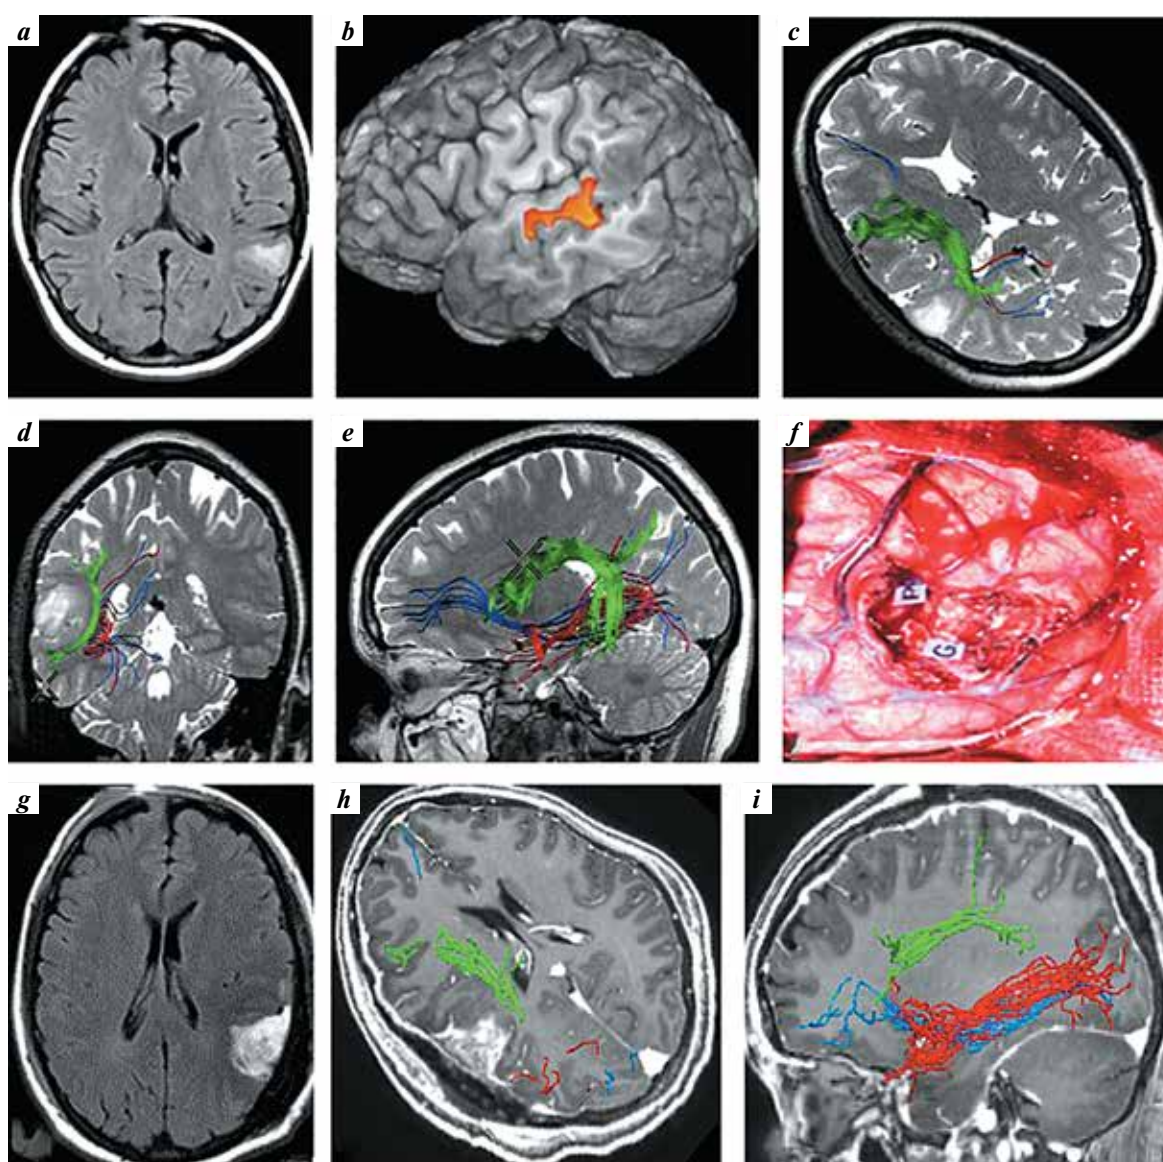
Data of female patient R.: a – magnetic resonance imaging (MRI) before surgery: axial scan in FLAIR mode; b – preoperative functional MRI: Wernicke's area is shown in orange (located at the front of the tumor); c–e – magnetic resonance tractography before surgery: arcuate fasciculus (intact) is shown in green: it is located very close to the posterior border of the tumor; inferior fronto-occipital (shown in blue) and inferior longitudinal (shown in red) fasciculi are intact; f – intraoperative image: letters G and P denote the arcuate fasciculus; g – MRI after surgery: axial scan in T2 FLAIR mode; h, i – magnetic resonance tractography after surgery: arcuate fasciculus is shown in green; inferior fronto-occipital and inferior longitudinal fasciculi are intact
